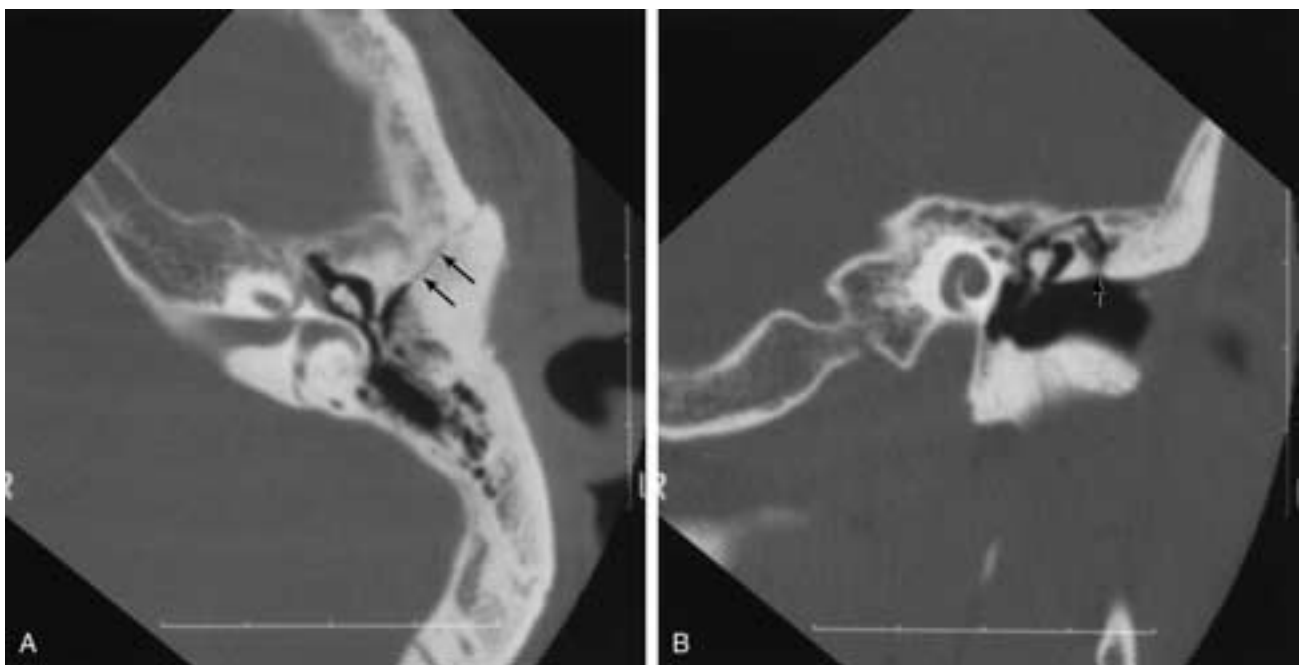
Longitudinal fracture. A, Axial CT image, left ear. Fracture line (*arrows*) is actually somewhat oblique to the long axis of the petrous bone. B, Coronal CT, left ear. Involvement of the EAC/tegmental air cell system (*arrow*).
